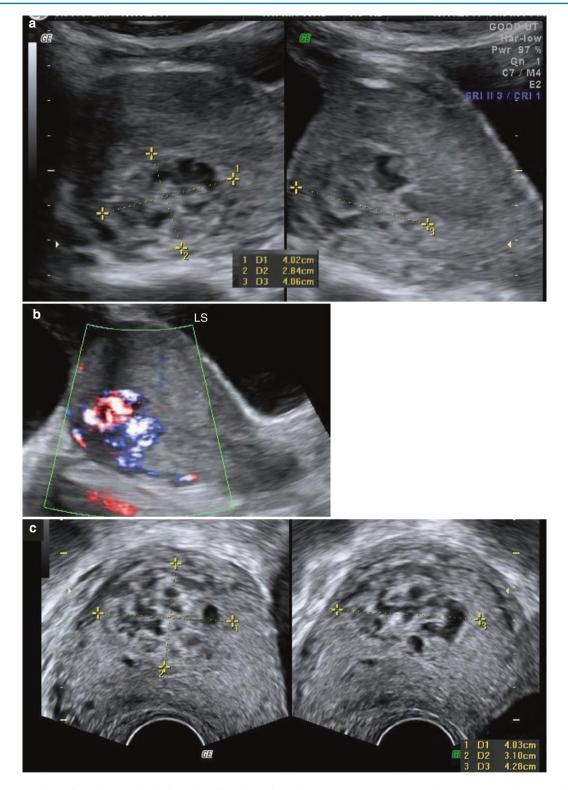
Persistent GTD with a probable diagnosis of invasive mole. Patient had a molar pregnancy which was evacuated elsewhere (2 months prior to this scan). Following this, the patient had bloating sensation, abdominal pain and bleeding. Patient was later diagnosed to have persistent GTD with a beta hCG of 21,306 mIU/mL for which she had undergone five rounds of chemotherapy. She discontinued treatment a week prior to this scan since she found no relief of symptoms. Beta hCG 2 weeks prior to scan was 38,292 mIU/mL and on the day of the scan, had dropped to 6,117 mIU/mL. (a) Transabdominal scan showing a vaguely circumscribed hyperechoic cystic area in the posterior myometrium of the upper corpus. (b) Same, showing high vascularity on Doppler; (c) TVS - showing a poorly circumscribed hyperechoic mass filled with cystic spaces in the myometrium. It was reaching up to the endometrium. The EMJ in this area was not well defined. (d) Abundant flow and multidirectional flow seen in the mass on Doppler, as is seen in complete moles. (e) Flow showed PSV of 38 cm/s and RI of 0.35. (f) Glass body rendered image showing the vascular mass within the uterus. (g) Bilaterally enlarged ovaries showing multiple theca lutein cysts. The image (g) shows the typical a 'spoke wheel' appearance. (h) Minimal flow is seen in the thinned out ovarian tissue between the cysts. (i) 3D rendered image of the theca lutein cysts
